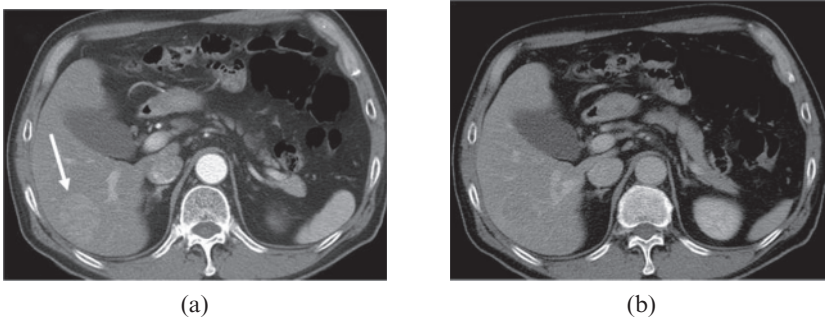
Contrast-enhanced axial CT image of the liver: (a) arterial and (b) equilibrium phase.
